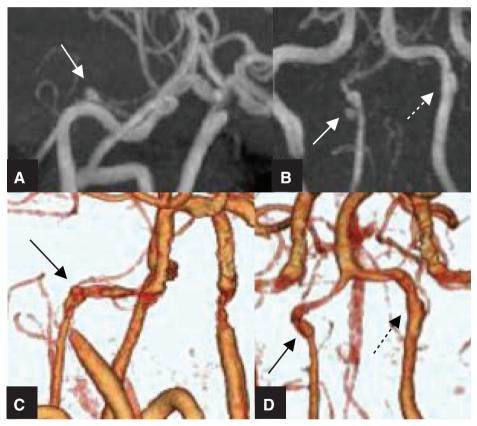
MRI (A and B) and CT (C and D) on Day 12. (A and C) Lateral view showing a dissecting right vertebral artery aneurysm (3 × 4 mm) and narrowing (pearl and string sign) (solid arrows). (B and D) Frontal view showing a dissecting right vertebral artery aneurysm (solid arrows) and wall irregularity in the left vertebral artery (dotted arrows).
